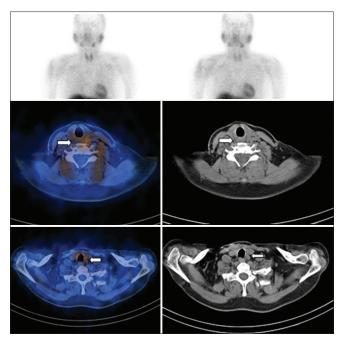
^{99m}Tc-sestamibi scintigraphy of a 51-year-old female with persistent primary hyperparathyroidism with no obvious parathyroid lesion visible. Axial SPECT/CT images demonstrating two non-MIBI avid right superior (white arrow middle row) and left inferior lesions (white arrow bottom row). SPECT/CT: Single photon emission computed tomography/ computed tomography
